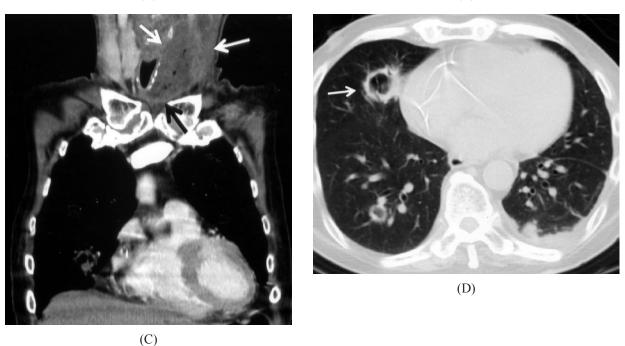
(A) Magnetic resonance imaging of the neck at presentation reveals a rim-enhancing cystic lesion at the left lobe of the thyroid gland, measuring $53 \times 45 \times 60$ mm in size (arrow). The trachea was pushed to the right side. (B) Computed tomography (CT) of the neck 2 weeks later showed left thyroid abscess (arrow) with air pockets after incision and tube drainage. The surrounding wall of the abscess is interrupted. (C) Coronal view discloses extension of the thyroid abscess to the deep neck. (D) CT of the chest also shows multiple cavitary nodules and consolidations at the bilateral lungs.
